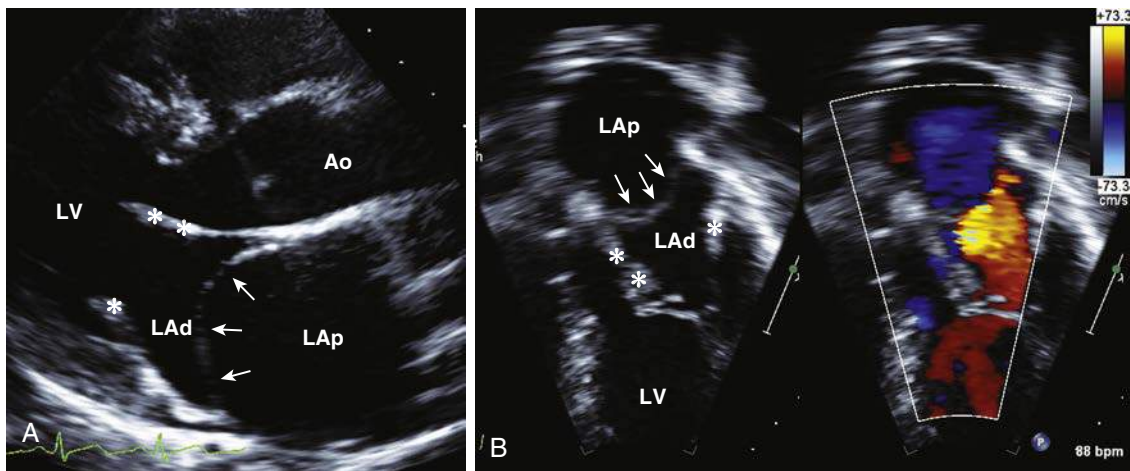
Transthoracic echocardiography of cor triatriatum sinister. A, Parasternal long-axis view from a patient with cor triatriatum during ventricular diastole. White arrows: cor triatriatum membrane; white asterisk: mitral valve. B, Apical three-chamber view from a patient with cor triatriatum during diastole. Color Doppler flow (right image) demonstrates flow acceleration at the level of the cor triatriatum membrane. White arrows: cor triatriatum membrane; white asterisk: mitral valve. Ao, Aorta; LAp, left atrium, proximal chamber; LAAd, left atrium, distal chamber; LV, left ventricle.
